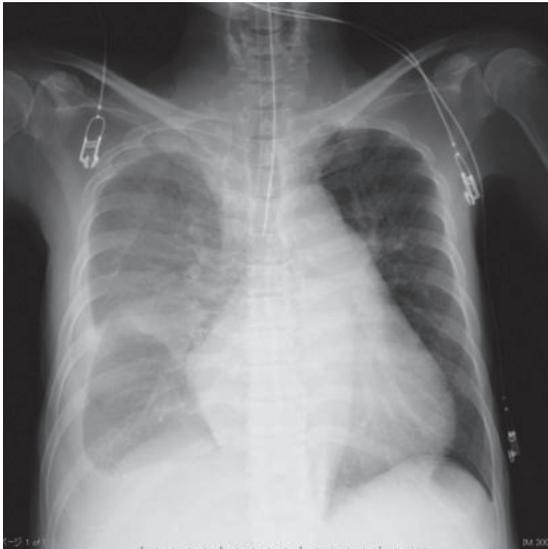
X-ray of the chest on admission.
